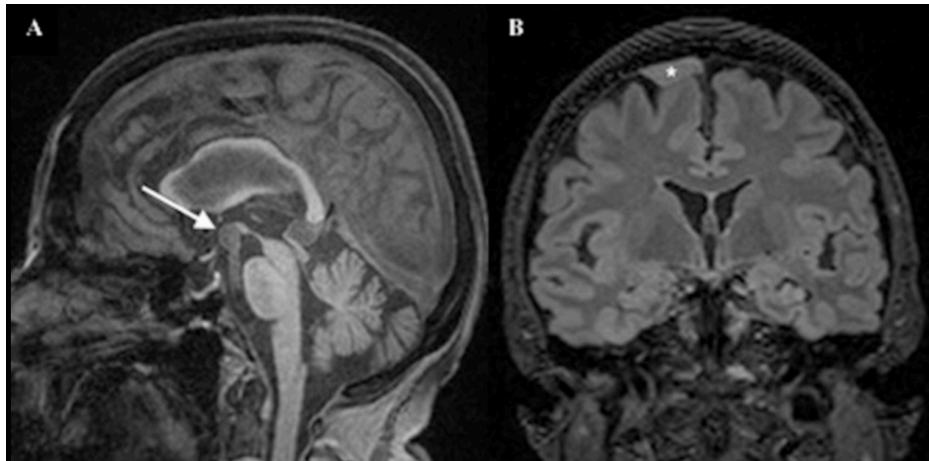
Examples of incidental findings detected on brain MRI in phase one
